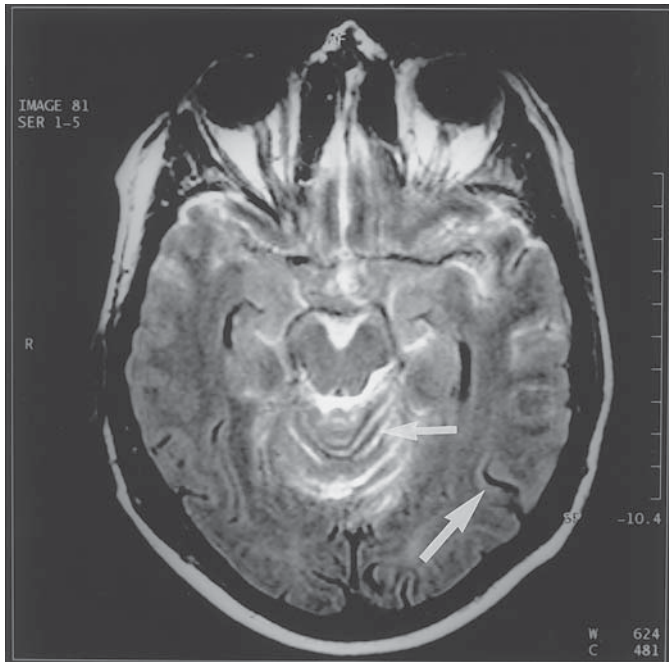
Leptomeningeal metastasis; MRI FLAIR image. Hyperintensity of arachnoid and pia (white, small arrow) signifies leptomeningeal seeding. Uninvolved arachnoid is hypointense (black, large arrow).
